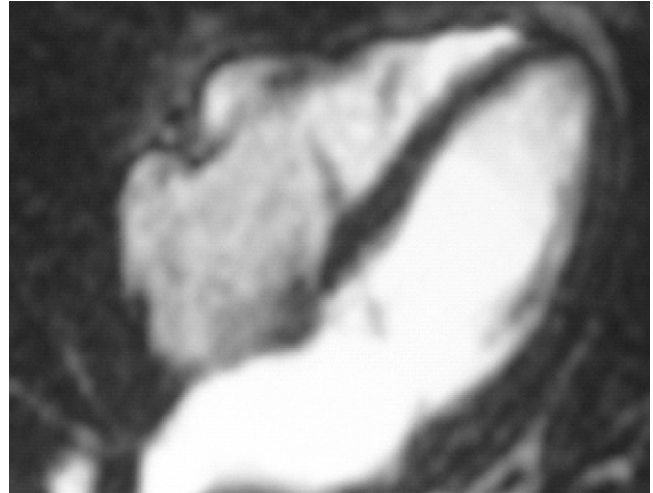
Magnetic resonance imaging showing needle.
